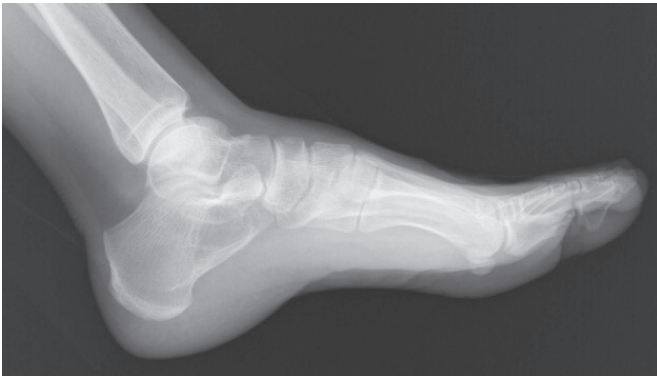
Lateral preoperative X-ray of a calcaneal lipoma
